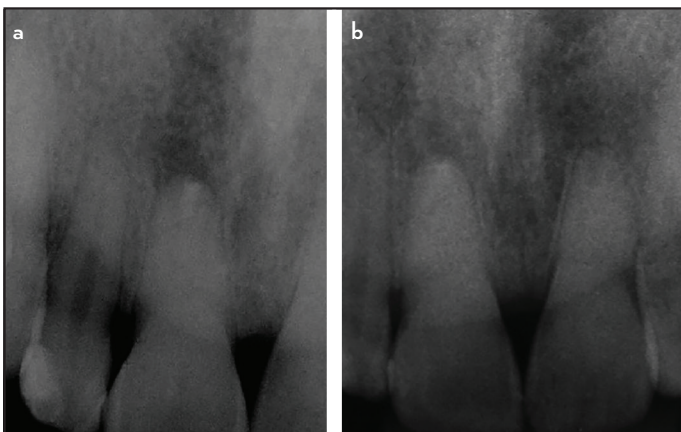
a, b. (a) Radiography at six months after surgical procedure, (b) follow-up radiography at 53 months from surgical procedure
